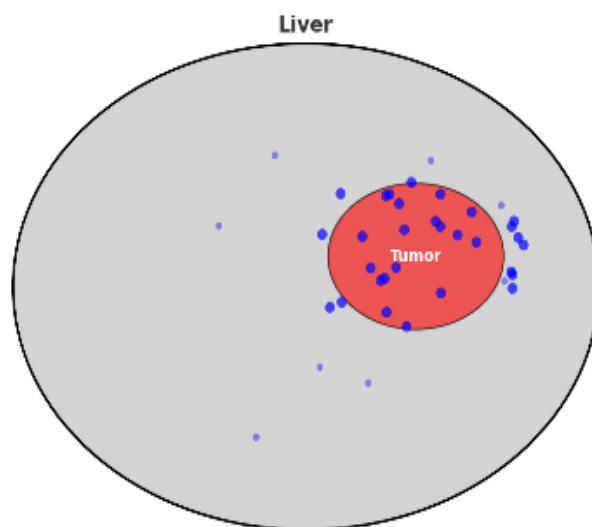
MRI scans showed high intratumoral concentration in experimental arm, confirming enhanced tumor targeting.
